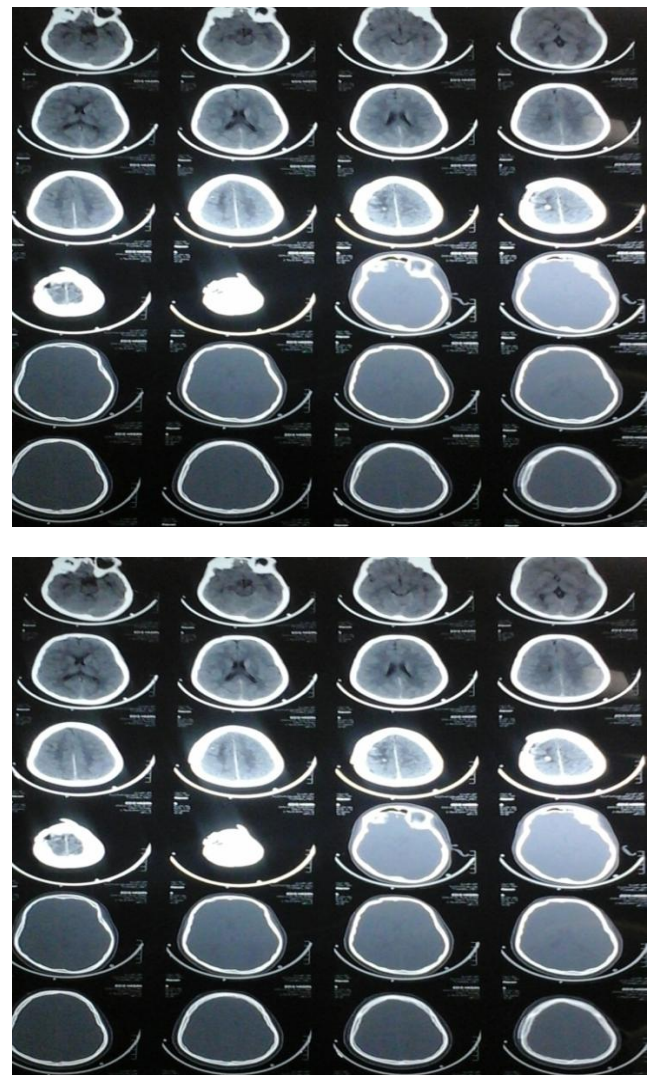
The depressed bone before its elevation (top); Post-operative CT brain of Case 3 (bottom)
